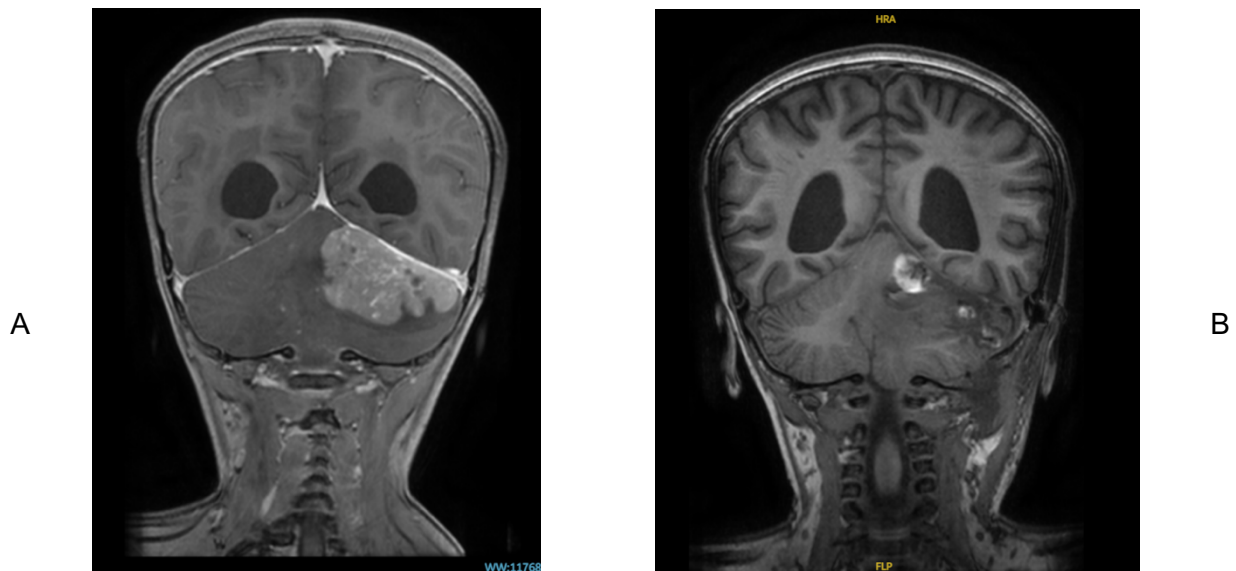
Child 2's pre- and postoperative MRI images of a left cerebellar mass. (A) Preoperative scan showing the presence of a left cerebellar mass. (B) Postoperative scan demonstrating complete removal of the mass
